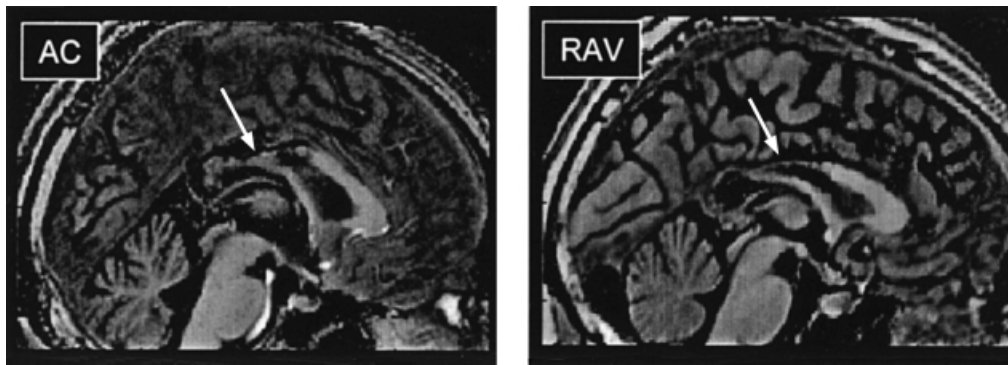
Sagittal MRI brain sections in two patients (A.C. and R.A.V.) with posterior callosal lesions (white arrows).
